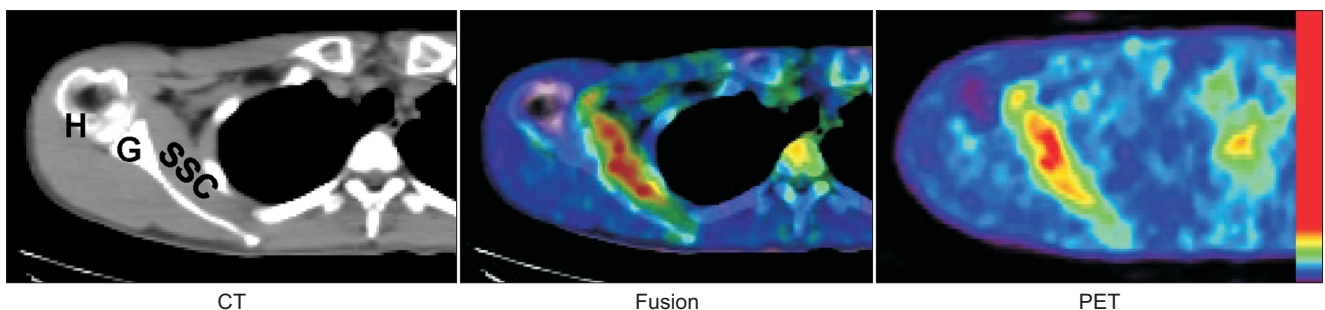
Fused image of positron emission tomography (PET) and computed tomography (CT). Each PET image was fused to the corresponding CT image. H: humeral head, G: glenoid, SSC: subscapularis.
